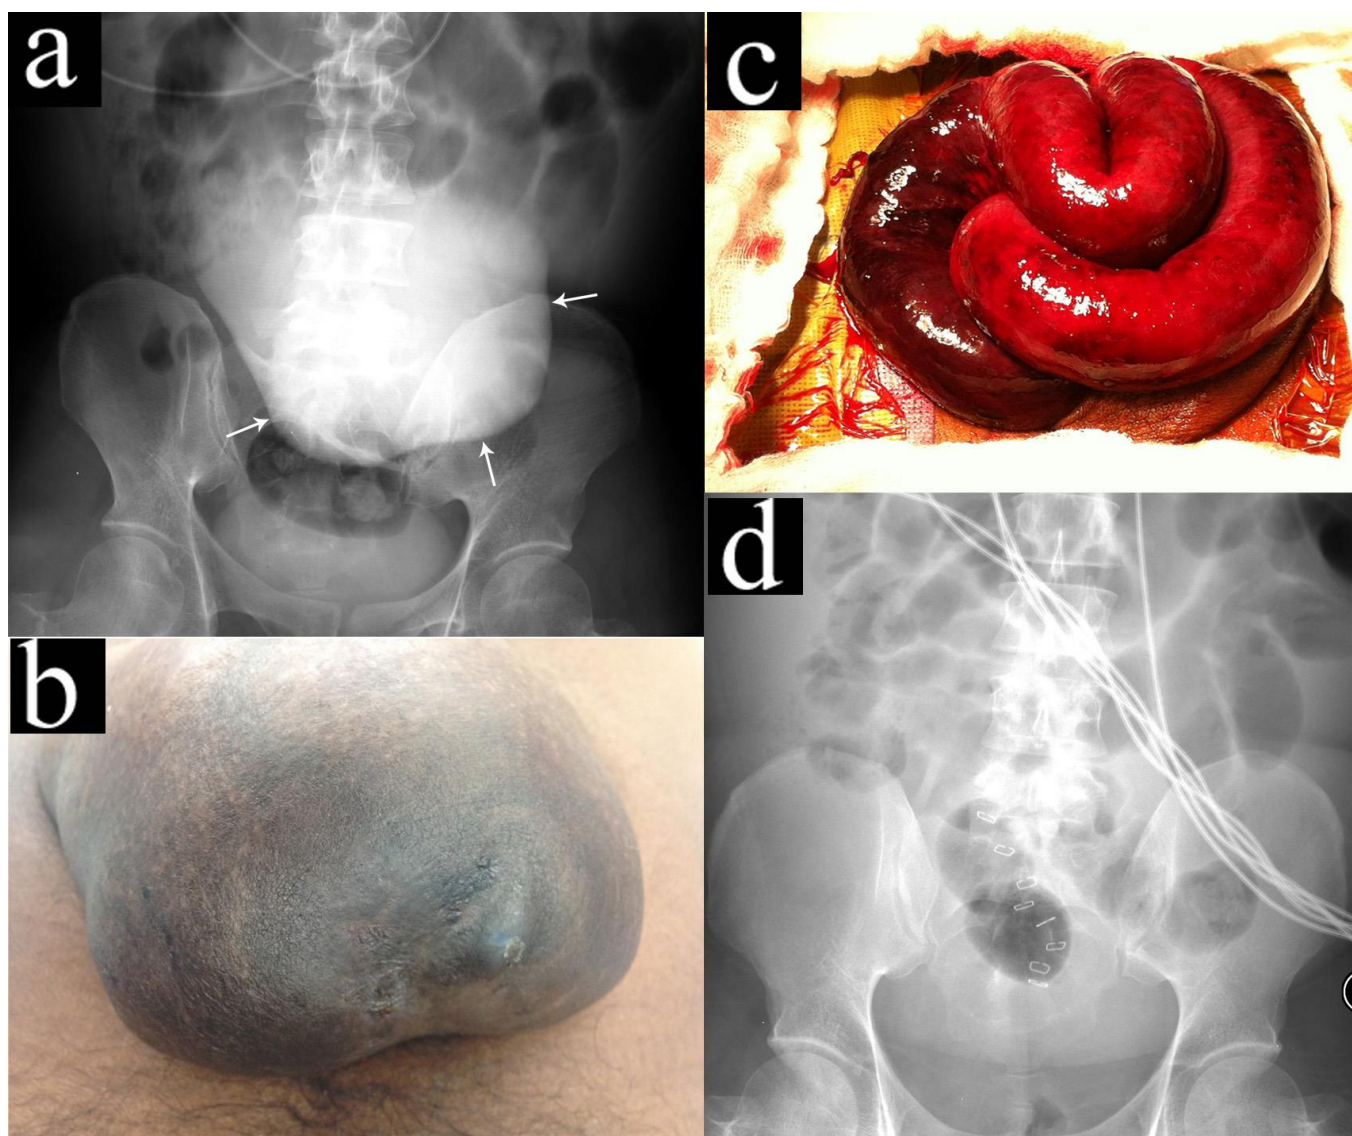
39-year-old man with asymptomatic reducible umbilical hernia and refractory ascites underwent a large volume paracentesis of 10 L. Within 48 hours after the procedure, he developed abdominal pain and distension and a tender irreducible umbilical hernia. Urgent laparotomy showed a strangulated umbilical hernia. FINDINGS: (a) Radiodense hernia sac (arrows) on preoperative supine radiograph of the abdomen. (b) Preoperative umbilical hernia sac on physical examination. (c) Intraoperative distended bowel loops in hernia sac with dusky discoloration reflecting non-viability. (d) Postoperative supine radiograph of the abdomen, showing resolution of the radiodense hernia sac.
